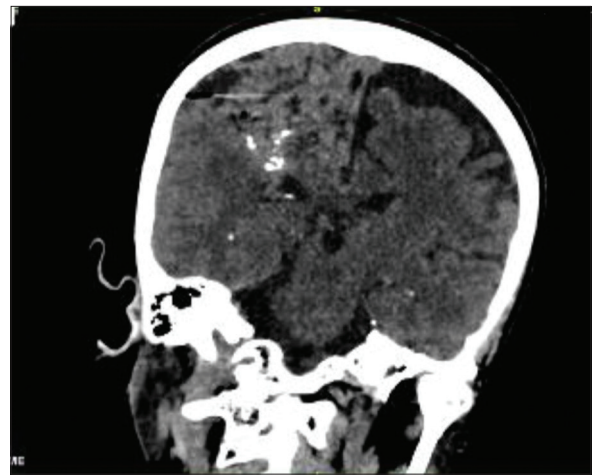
Native endocranial computed tomography, coronal projection: In the right frontoparietal lobes, central nervous system tissue is made of different consistency with multiple calcifications and hypoattenuating zones compared with rest tissue
